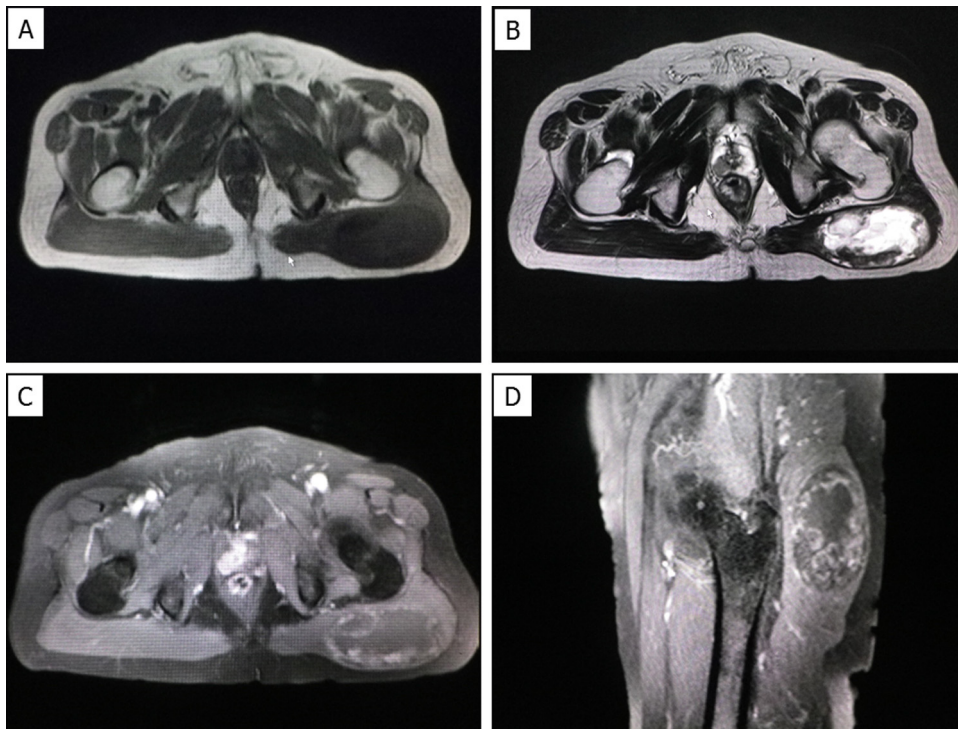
Magnetic resonance imaging (MRI) of the left buttock of a 77-year-old patient. MRI revealed a well-defined mass in the left buttock. The mass showed low signal intensity compared to the skeletal muscle on T1-weighted images (WIs) (A) and heterogeneously high signal intensity on T2-WIs (B). The mass had heterologously mixed low to slightly high signal intensity compared to the skeletal muscle on fat-suppressed T1-WIs (C: coronal, D: sagittal).
